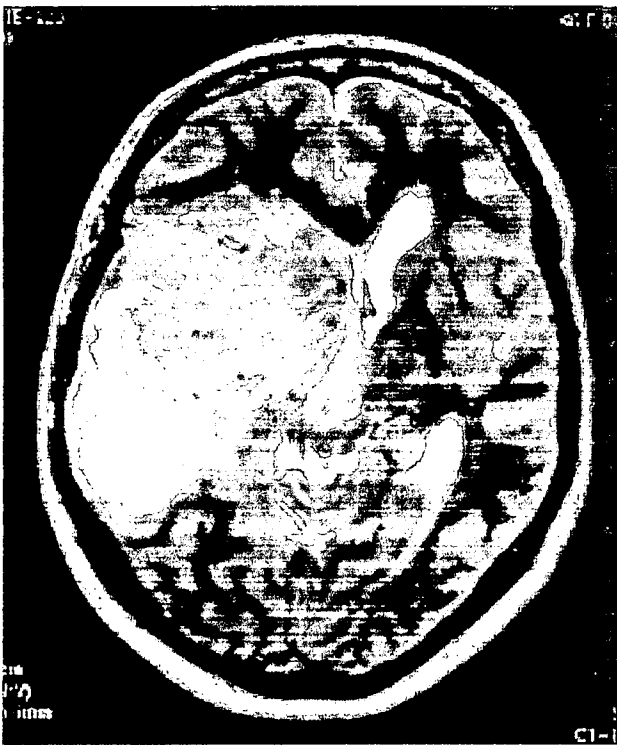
MRI demonstrates a tumor measuring 5 cm in diameter, with surrounding edema, in the right temporal lobe.
